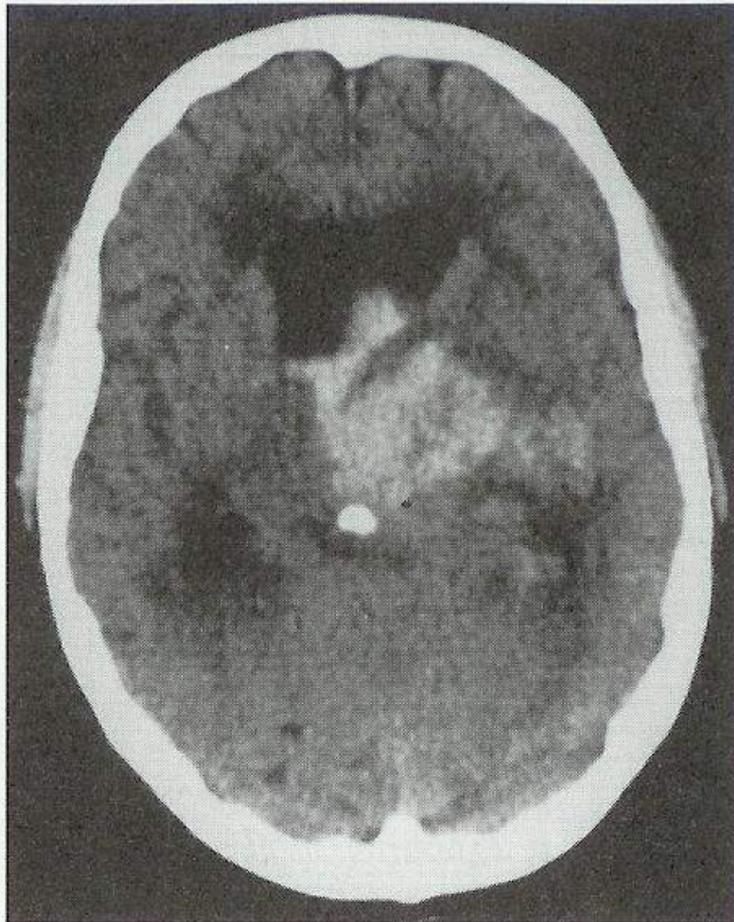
Massive right putaminal (intracerebral) hemorrhage seen on two planes of the non-contrast computed tomography brain scan. There is associated intraventricular extension. The size of the hematoma and the ventricular extension are both poor prognostic signs.
